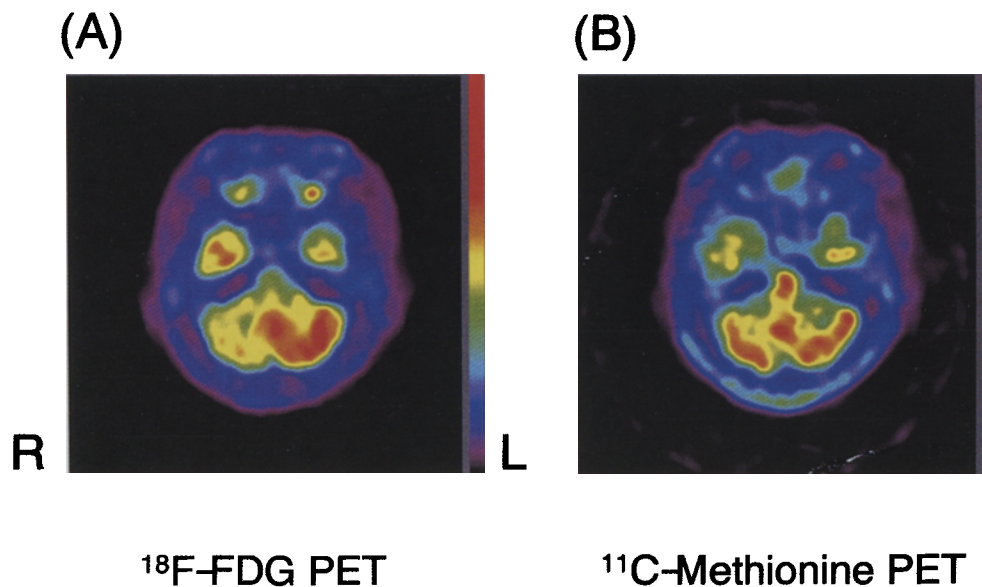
The FDG and MET images in a CCD-positive patient with brain tumor located in the left frontal lobe. (A) The FDG PET image shows a significant decrease in the FDG uptake in the right cerebellar hemisphere as compared with that in the left cerebellar hemisphere. The asymmetry index was 0.235. (B) The MET PET image shows little decrease in the MET uptake in the right cerebellar hemisphere as compared with that in the left cerebellar hemisphere. The asymmetry index was 0.021.
